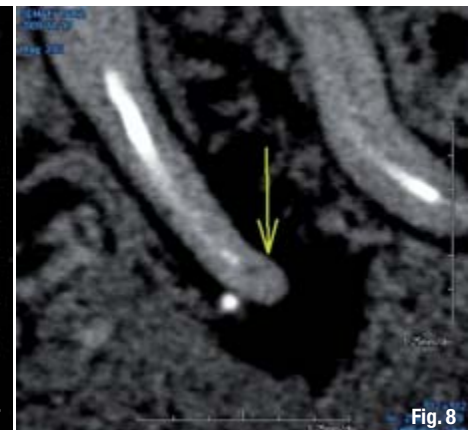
\_ The 3-D CBCT showing anatomy of the maxillary sinuses.
